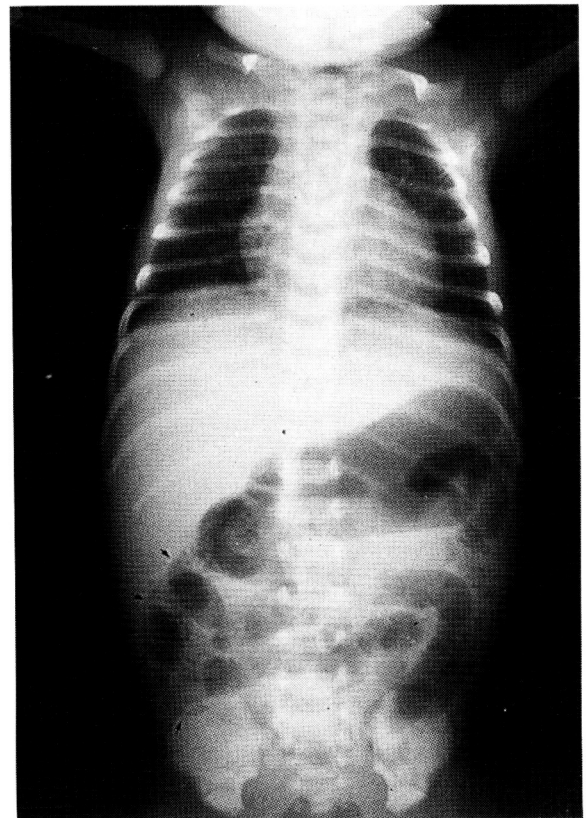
Plain radiograph shows pneumatosis intestinalis (arrows) in the right abdomen and slightly dilated bowel loops.
